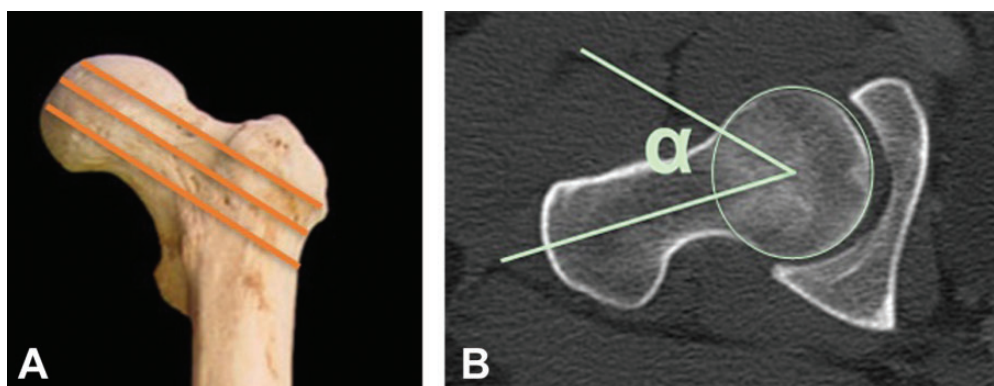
Alpha angle measurement. (A) The 3 cephalic, medium, and caudal neck levels were determined. (B) Measurement in the second level in an oblique axial computed tomography of the femoral neck.
